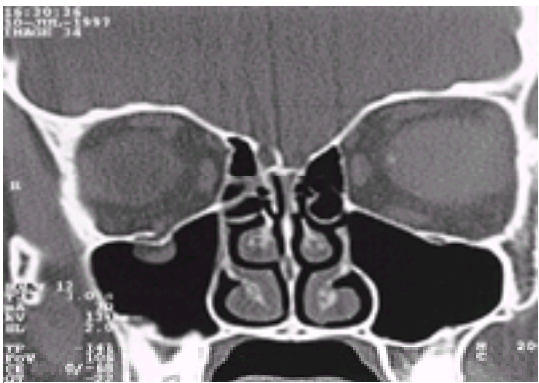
Coronal CT scan demonstrating small right sided blow-out fracture with entrapment of inferior rectus muscle. The patient complained of diplopia on upward gaze.
